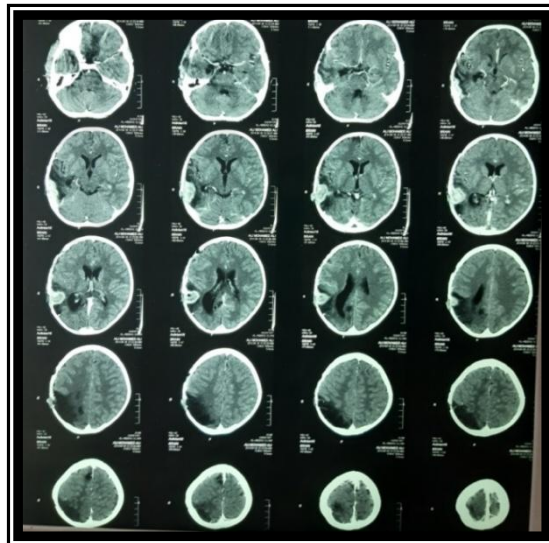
Axial CT brain with contrast showing subdural collection of pus
